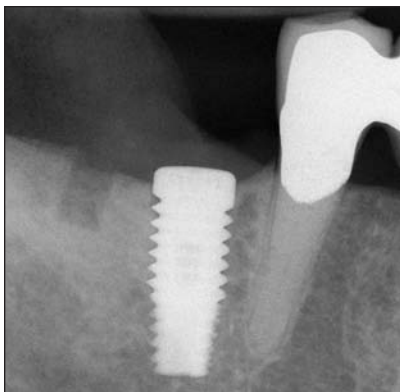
Case 1. 9-month re-entry. Radiographic appearance immediately after implant placement. Note the radiotransparent region of the bone biopsy.
